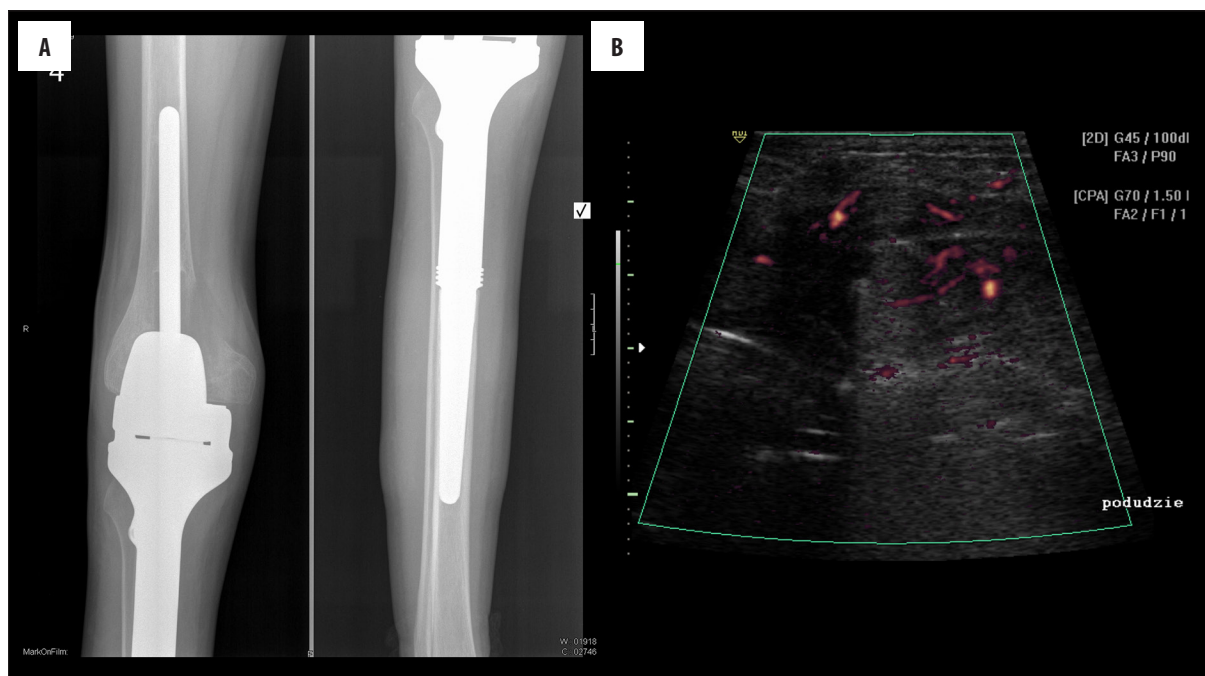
15-year-old boy with tibial osteosarcoma one year after implantation of prosthesis. (A) X-ray: osteolytic defect in the medial femoral condyle. (B) Ultrasonography: solid tumor next to the defect with rich vascular supply. Disease recurrence in the femur was diagnosed.
